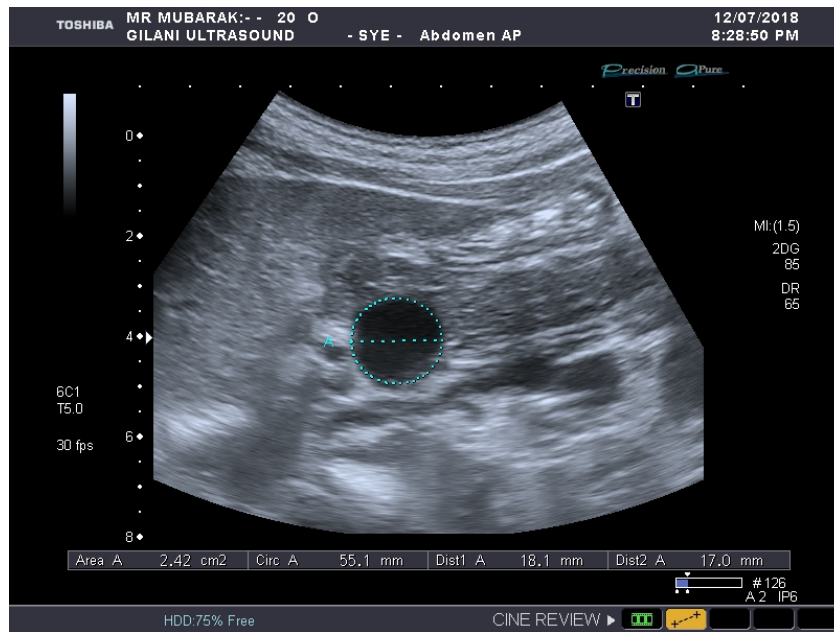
Ultrasound image showing the increased diameter of the portal vein in CLD.
